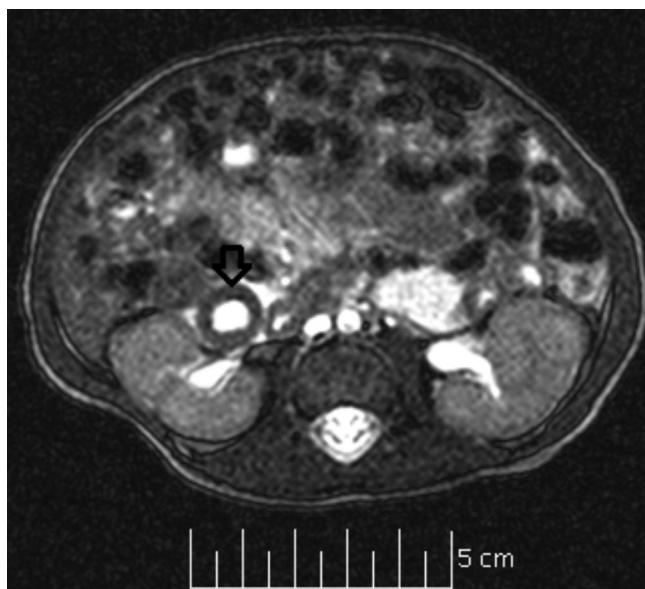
Magnetic resonance imaging of abdomen revealed a 1.7cm x 1.2cm x 1.3cm fluid-containing structure with a uniform 3-mm wall (arrow) adjacent to the duodenal.
